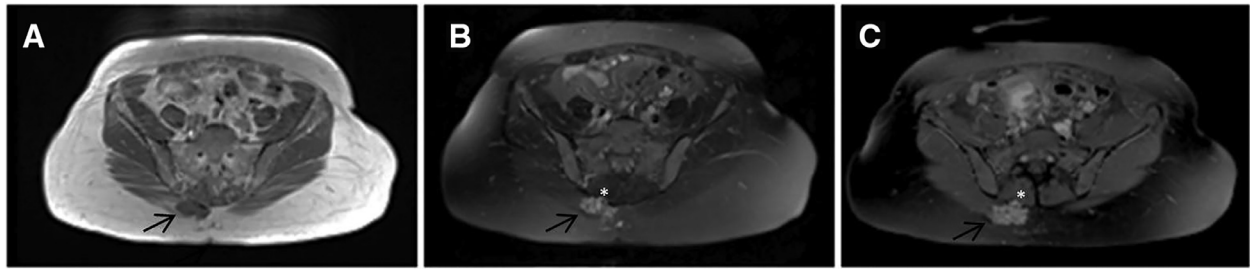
Axial MRI images of the lower back at the time of the recurrence. T1-weighted image (A) showing a hypointense lobulated mass (arrow), hyperintense on T2 fat-suppressed sequence (B) and avid enhancement with gadolinium contrast (C). Adjacent muscle invasion is also observed in these images (*).
